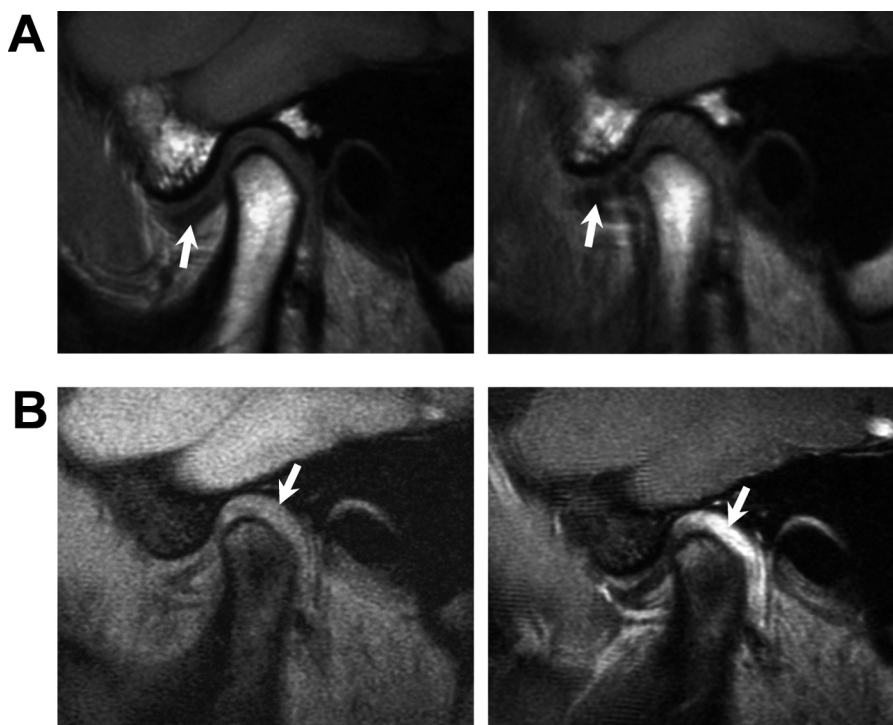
(A and B) A 18-year-old woman with a recent history of right TMJ pain and clicking. (A) Sagittal T1-weighted closed- (left) and open-mouth (right) MR images show anterior disk displacement without reduction (arrows). (B) Sagittal dynamic fat-suppressed T1-weighted pre- (left) and postcontrast (right) MR images demonstrate inhomogeneous prominent enhancement of the posterior disk attachment (arrows). TMJ, temporomandibular joint.
